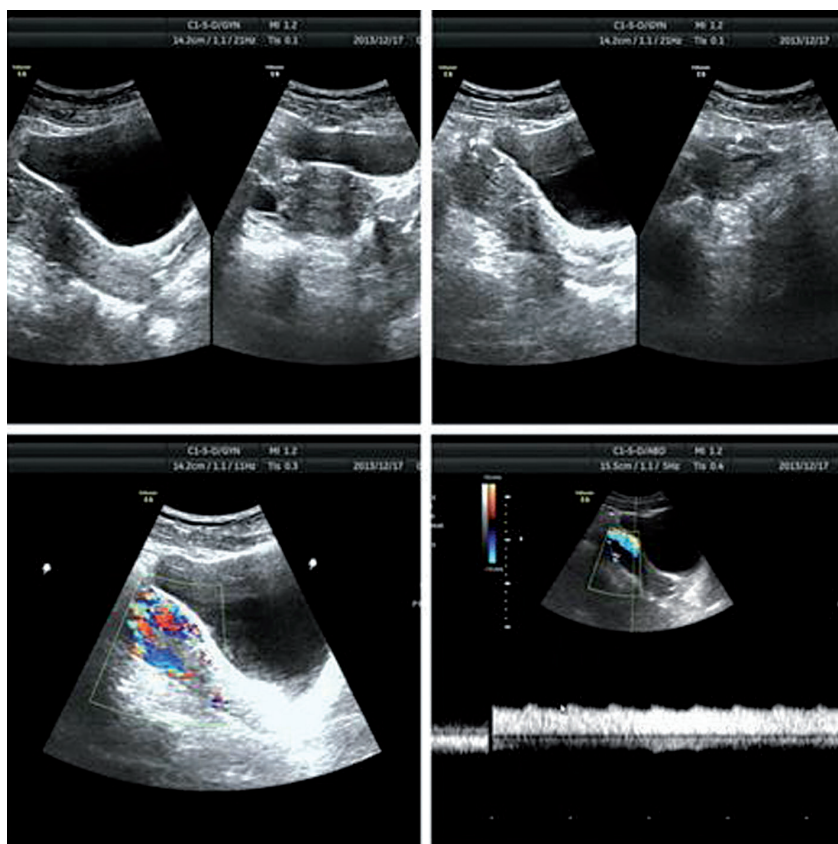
Color ultrasonography performed on December 16, 2013 after surgery.
